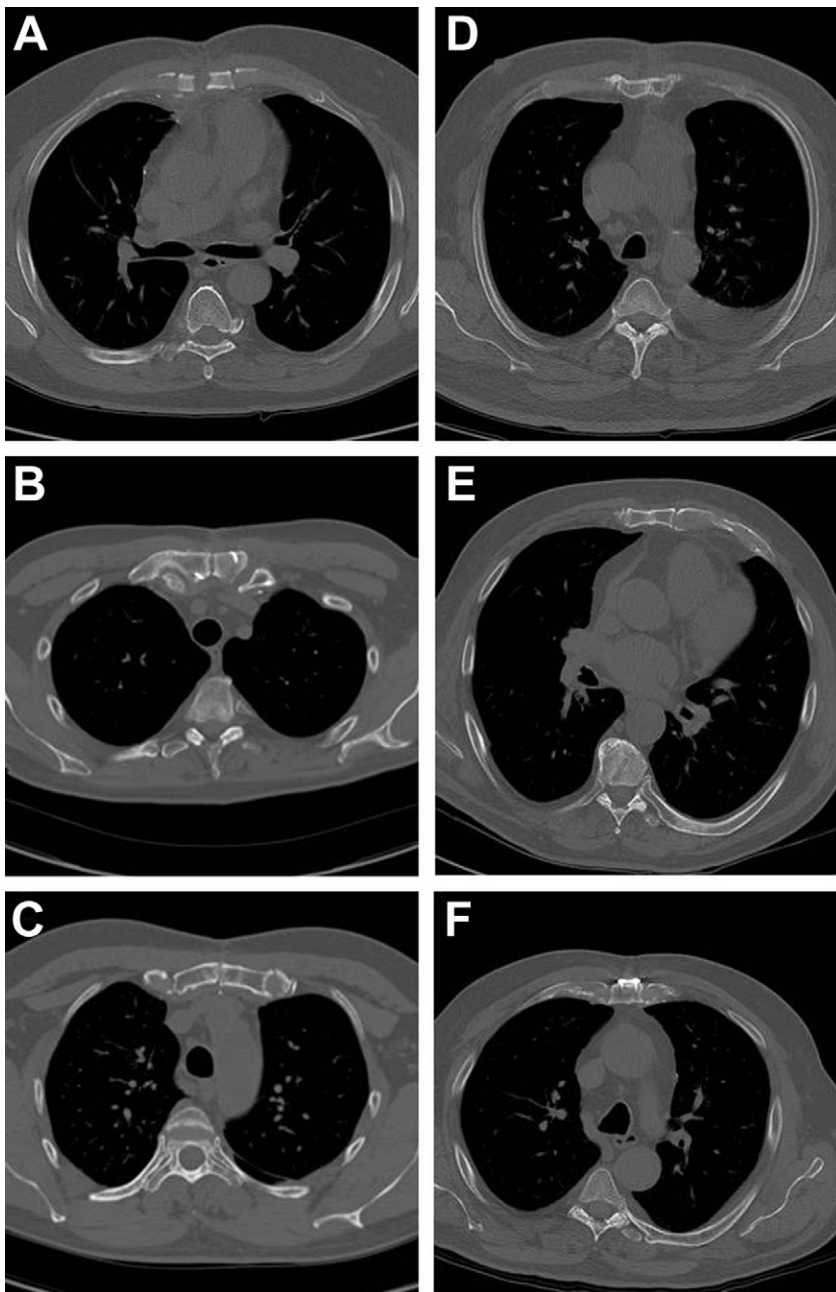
Axial computed tomography scan images representative of each score on 6-point scale. Each score was defined as follows: (A) 0 = no sign of healing (clear lack of healing, nonunion, sternal separation); (B) 1 = minimal healing (sternal separation, lack of bridging bone); (C) 2 = mild healing (sternal separation with hazy, immature bone formation); (D) 3 = moderate healing (partial bridging bone indicative of sternal stability); (E) 4 = partial synthesis (significant bridging bone); and (F) 5 = complete synthesis (complete bridging bone).
